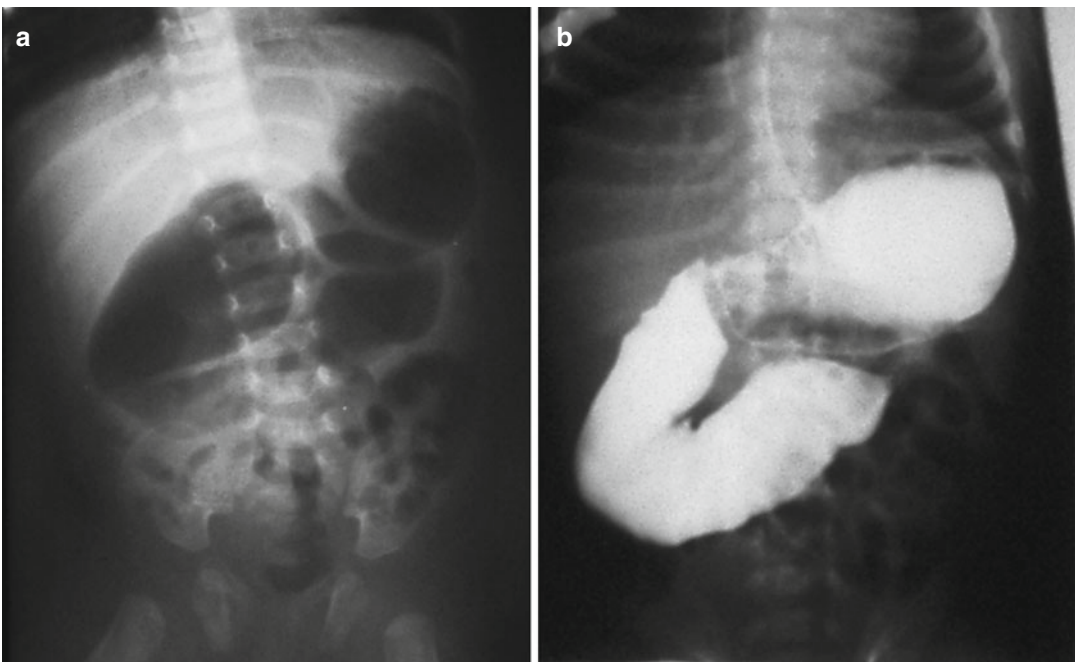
(a) Radiograph shows dilatation of the stomach and duodenal loop. Gas is seen in jejunal loops. (b) Barium study demonstrated a jejunal stenosis at the level of Treitz ligament
